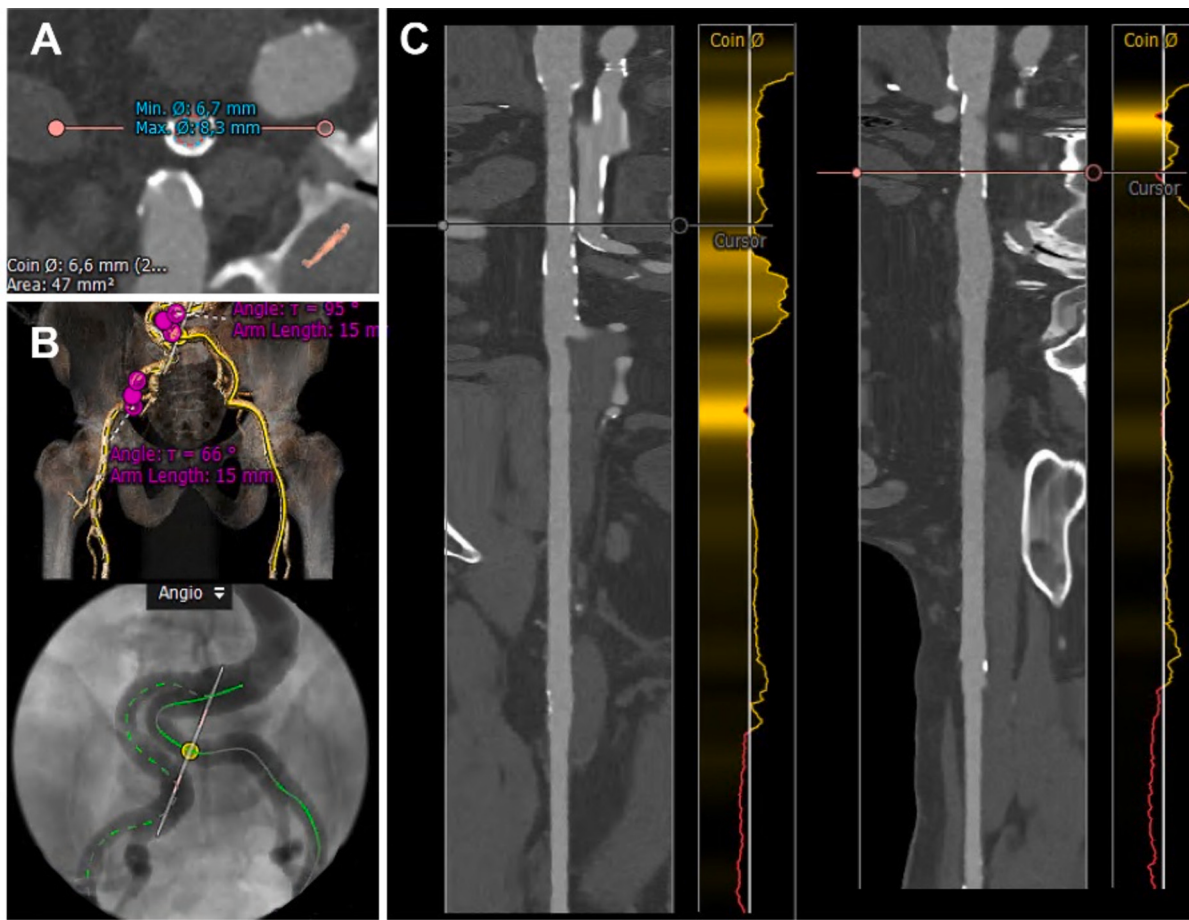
Computed tomography-analysis of the iliofemoral system using the 3mensio Valve™ software. A) Vessel diameter and area; B) Three-dimensional reconstruction model used for the absolute angle of the iliofemoral system; C) Centre-line reconstruction of the iliofemoral system to ensure measurements of vessel diameter and area perpendicular to the axis of the vessel.
